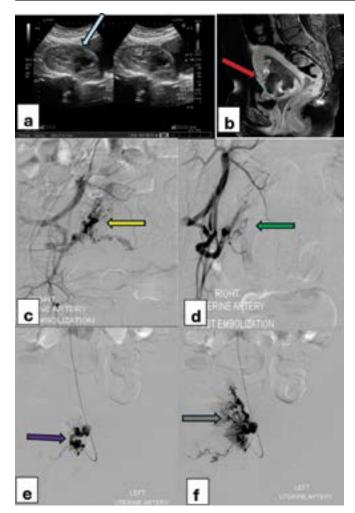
(a) Greyscale ultrasound image with heterogeneous area along anterior myometrium (White arrow) with cystic spaces. Cystic spaces are filled with colour on Doppler imaging leaving the centre avascular area. Findings represent uterine AV malformation with thrombosed vessels/hematoma in the centre. (b) Post contrast Sagittal MRI image showing dilated tortuous vessels (Red arrow) in the anterior wall of the uterus representing an AV malformation, non-enhancing area posterior to it represents hematoma/thrombosed pseudo-aneurysm. (c) & (f) Pre-embolization run of right and left uterine arteries (Yellow and grey arrows), shows abnormal bunch of vessels, dilated venous channels with formation of venous varices. (d) & (e) Post procedural angiogram of right and left uterine arteries (Green and Purple arrows), revealed complete embolization of vascular malformation.
